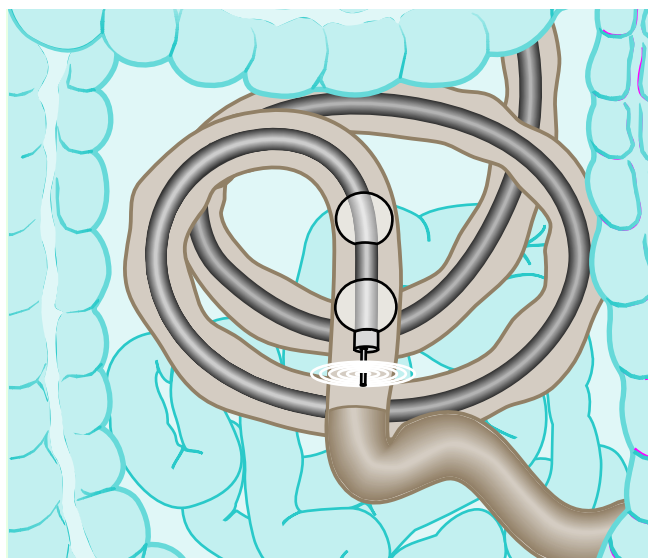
A typical position of the enteroscope in situ. The ultrasound transducer is protruding from the tip of the enteroscope.
